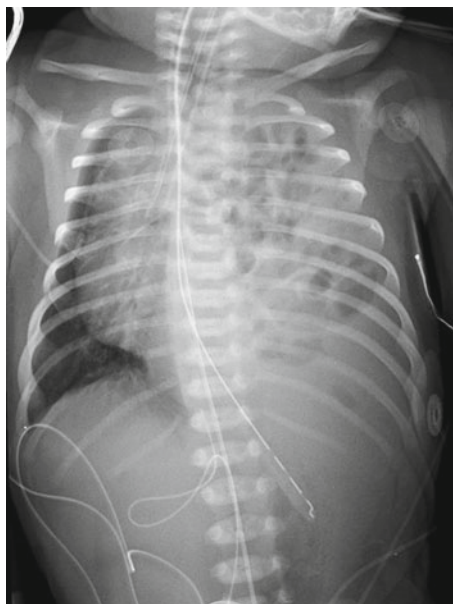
Chest radiograph of an infant with a left CDH
